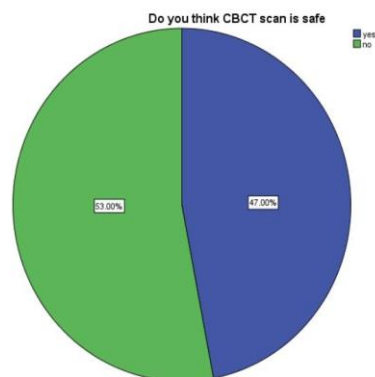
Pie chart shows the response about the safely of CBCT , 47% said yes and 53% said it is no easier. In this blue indicates yes and green indicates no.
